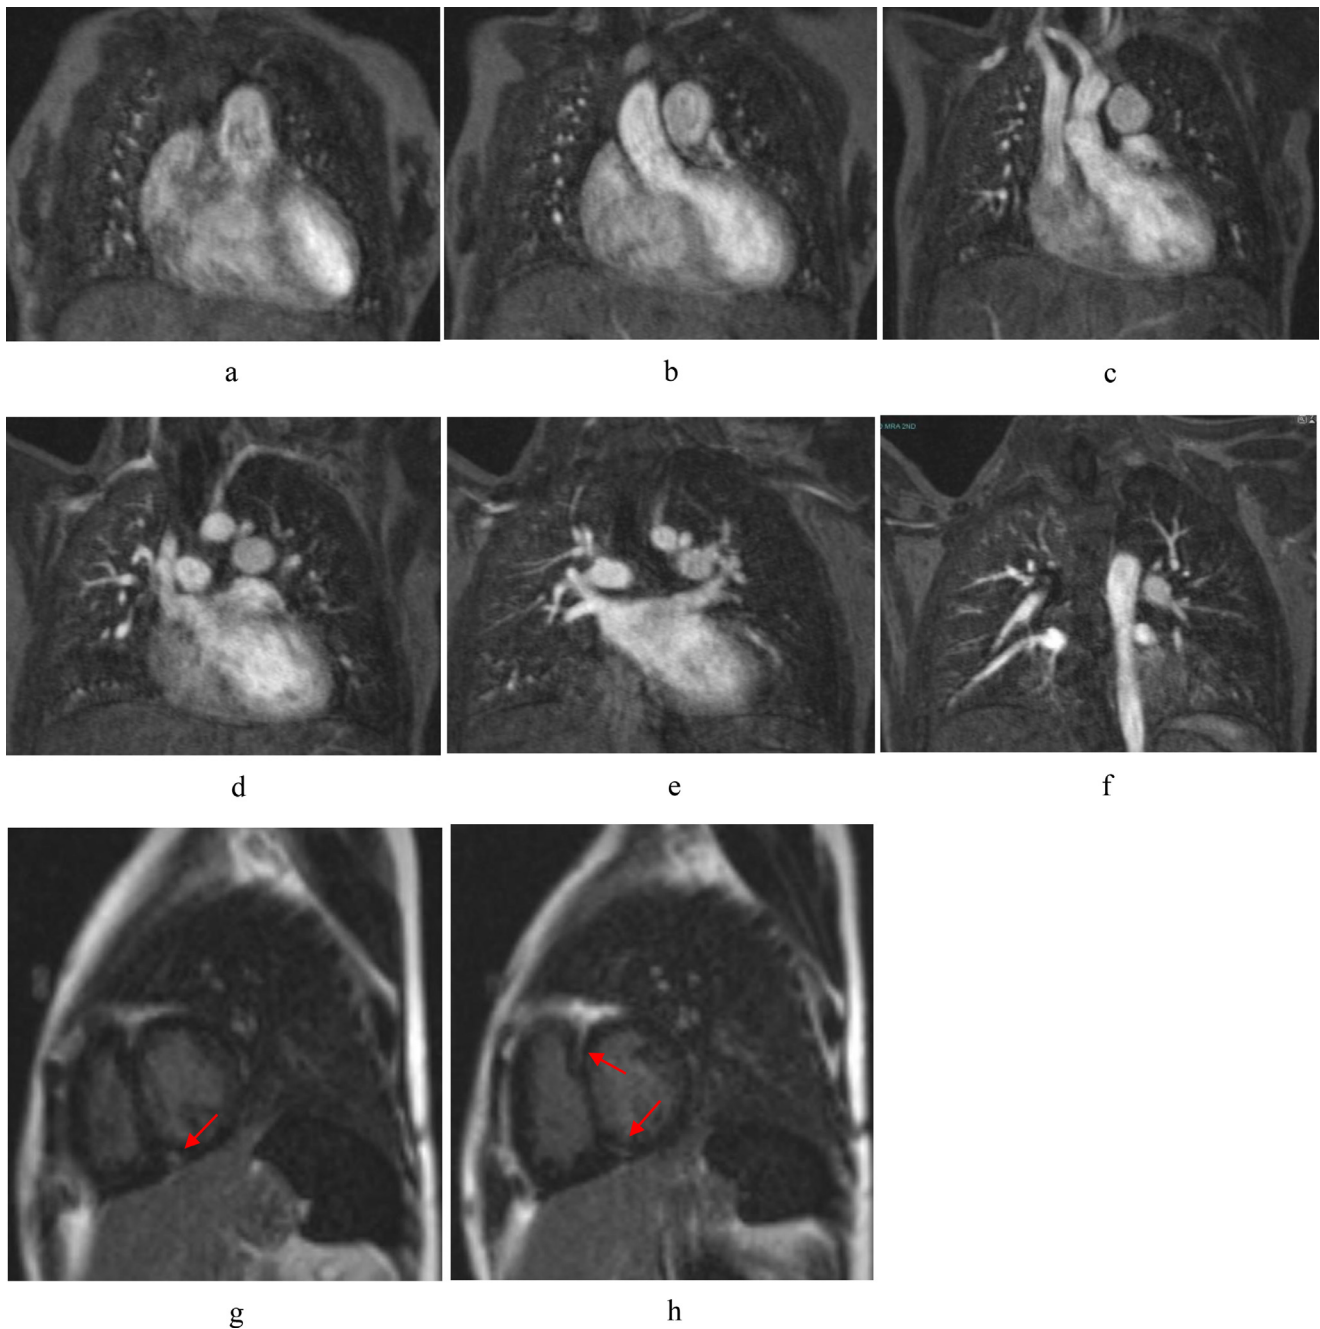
Coronal cardiac MRA (a-f) shows left pulmonary artery was the only branching artery from the pulmonary trunk, while the right PA was arising from the ascending aorta which was consistent with AORPA. Sagittal Cardiac MRI delayed gadolinium enhancement images (g,h) shows evidence of focal fibrosis on gadolinium up-take at mid RV/LV insertion points (red arrows).
